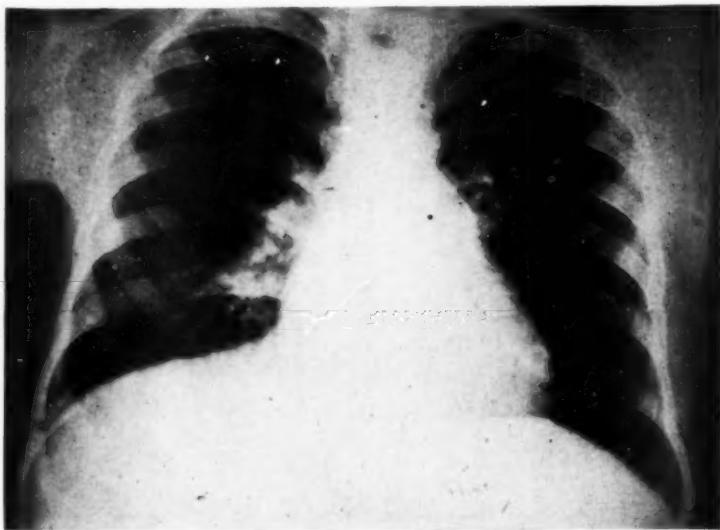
Roentgenogram of chest of Patient 5. "Mitral configuration" of the heart is demonstrated. There is evidence of bilharzic infiltration especially in the right lung; the right hilar shadow is accentuated.
